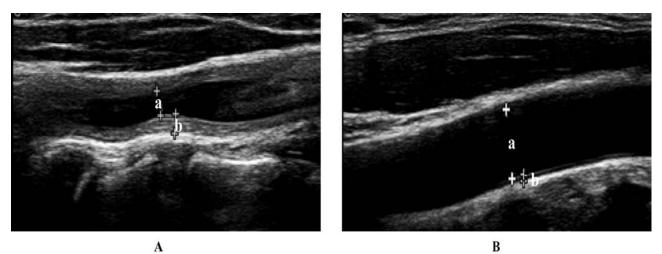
US variables of CCA in enrolled patients with TA. (A) A 48-year-old woman admitted to the hospital for > 1 month because of carotidynia, accompanied by sudden syncope. US measurement (left CCA): (a) diameter 2.30 mm, (b) IMT 1.80 mm, IDR 0.78, PSV 49.10 cm/s. (B) A 27-year-old woman admitted to the hospital for 3 years because of undetectable blood pressure of the right upper extremity, who had no neurological SIEs. US measurement (right CCA): (a) diameter 5.60 mm, (b) IMT 0.54 mm, IDR 0.09, PSV 79.70 cm/s. CCA: common carotid artery; IDR: intima-media thickness; PSV: peak systolic velocity; SIE: severe ischemic event; TA: Takayasu arteritis; US: ultrasonography.
